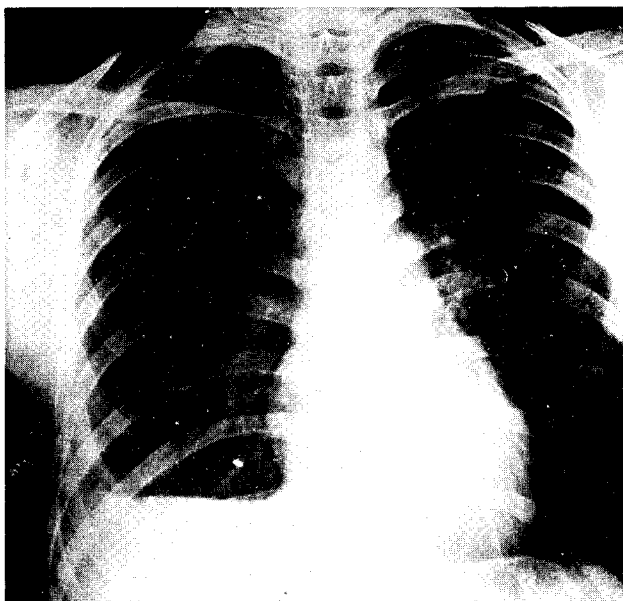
Roentgenogram of thoracic cavity of soldier who was prone in a foxhole when a Japanese hand grenade exploded at a distance of not more than 1 foot from the chest wall. This X-ray shows the characteristic small fragments of the hand grenade. Most of the fragments were stopped by the chest wall, but some of them penetrated the pleura. The fragmentation of the Japanese hand grenade is irregular but usually very small.
